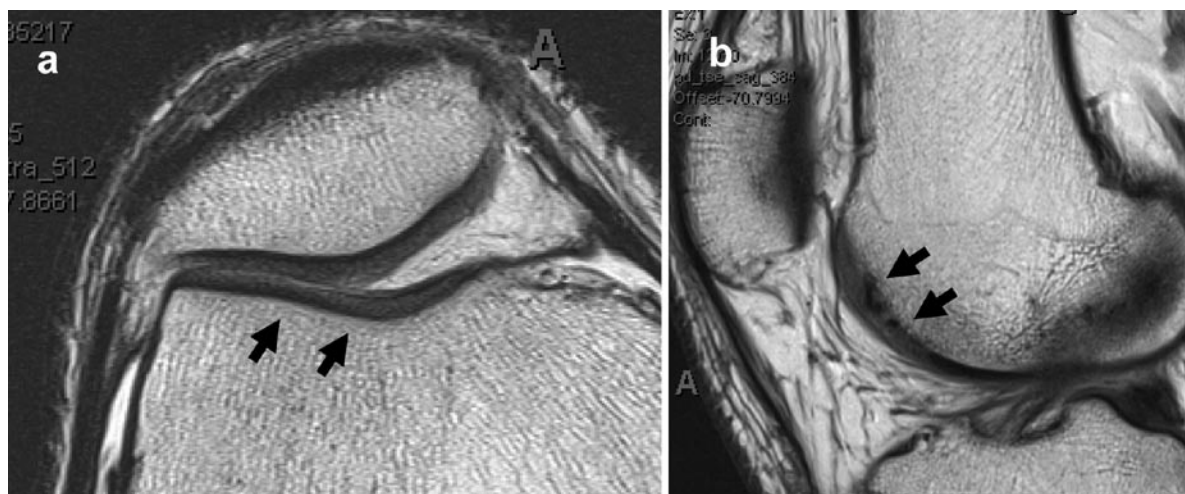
Structural MRI showing cartilage of the lateral trochlea (*arrows*). (a) Axial imaging shows slight disruption of the patellar cartilage surface with intact appearing trochlea. (b)
